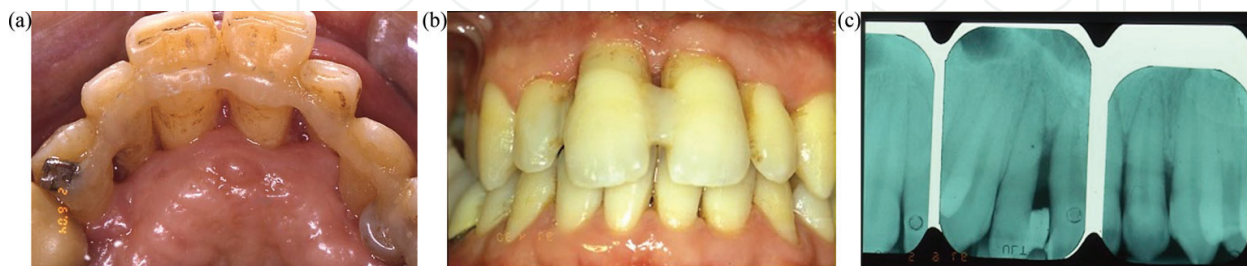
(a, b) Bulk lingual and vestibular splinting of teeth, which do not allow for appropriate oral hygiene maintenance. (c) Radiographic image showing the complete loss of periodontal support.
